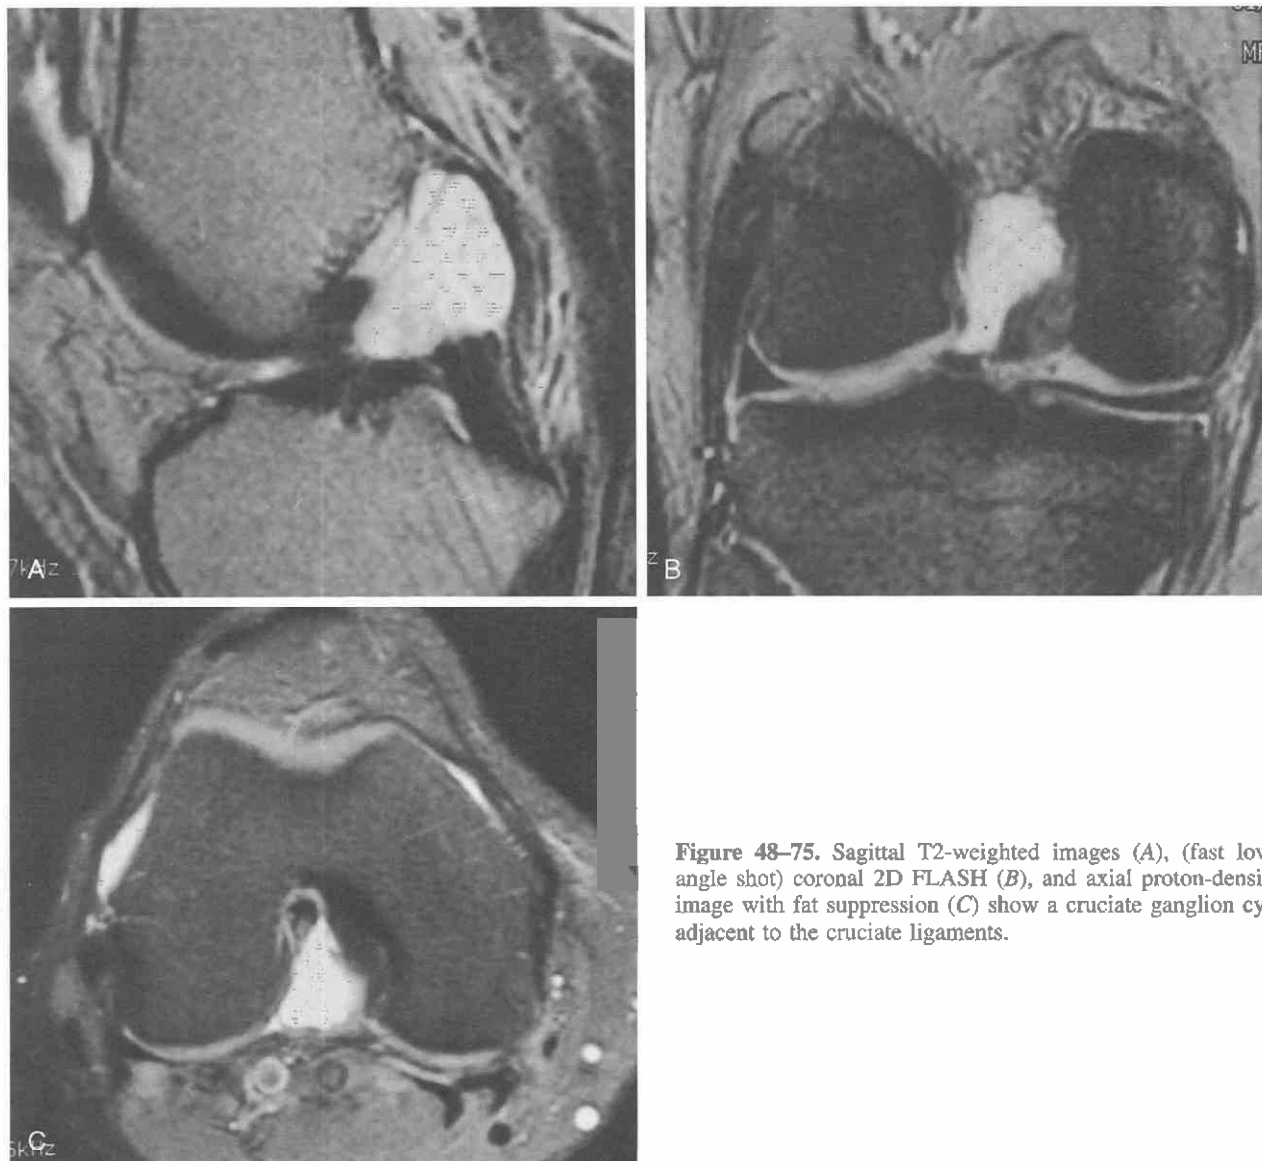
Sagittal T2-weighted images (A), (fast low-angle shot) coronal 2D FLASH (B), and axial proton-density image with fat suppression (C) show a cruciate ganglion cyst adjacent to the cruciate ligaments.
